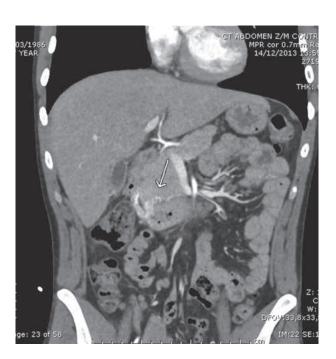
CT-scan in the arterial phase shows a large feeding artery and a racemose vascular network in the wall of the inferior part of the duodenum.
